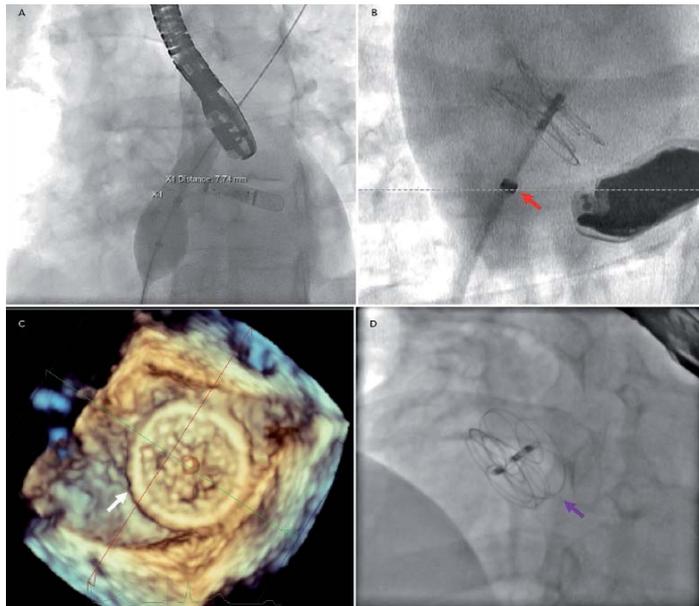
The PFO closure procedure. (A) Wire crossing a PFO into the left upper pulmonary vein. A sizing balloon is deployed and the quantitative angiographic analysis to size the defect is shown. (B) The Gore Cardioform septal occluder has been deployed through the delivery sheath (red arrow) but has not yet been released. (C) 3D transesophageal echocardiography image of the device (white arrow) viewed from the left atrium. (D) The device is shown in place after release (purple arrow). Reproduced with permission from *Interventional Cardiology Review* 2019;14(1):34–41.
